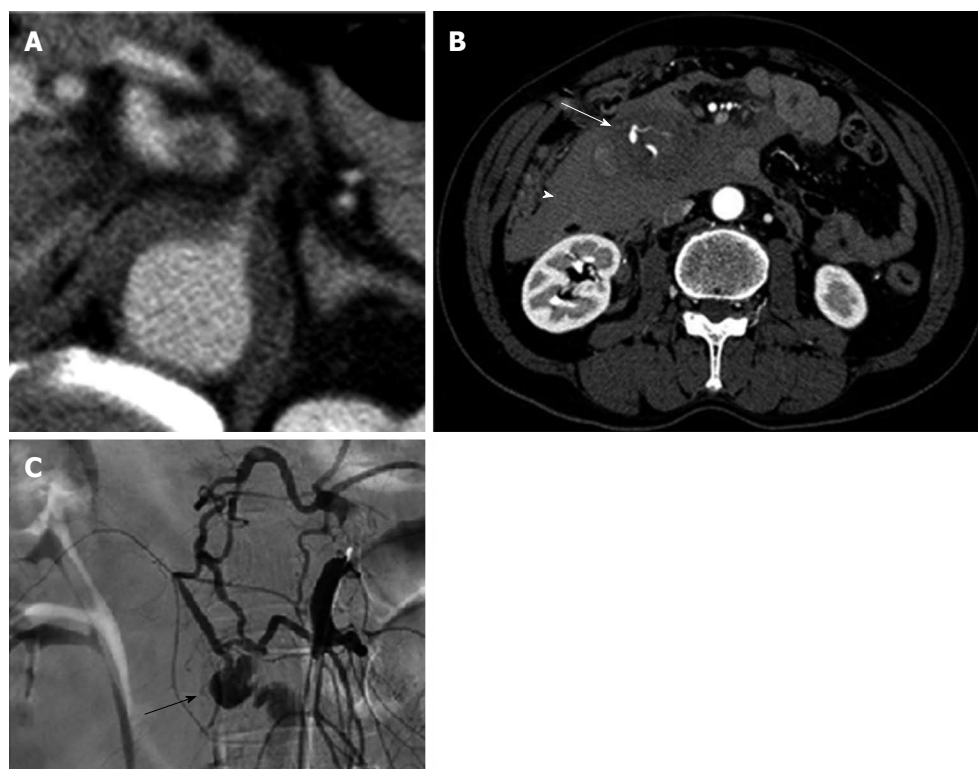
Subsequent contrast-enhanced computed tomography and arteriography performed at our hospital, after the onset of hypotension. A: Multidetector computed tomography (CT) performed at our hospital showing the root of the coeliac artery compressed and occluded by the false lumen more clearly than that performed at a local hospital; B: CT scan showing a large haematoma in the right prerenal space (arrow head) and the aneurysm of anteroinferior pancreaticoduodenal artery (arrow); C: Arteriogram of the superior mesenteric artery (SMA) showing blood flow reversal from the SMA to the hepatic artery through the pancreaticoduodenal arcade, due to coeliac trunk occlusion and a saccular aneurysm of the inferior pancreaticoduodenal artery (PDA) (arrow).
